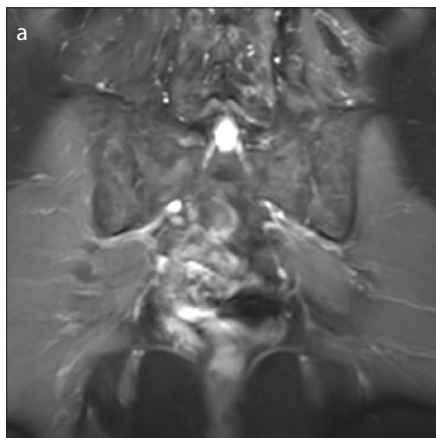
a–e. A 78-year-old female presenting with buttock pain and back pain and diagnosed with left piriformis syndrome. She received an injection without Botox and had a negative response. Coronal 3D IR TSE image (a) shows normal signal of the sciatic nerves. Coronal MIP DTI image ($b=600 \text{ s/mm}^2$) (b) shows no enhancement of the sciatic nerves. Axial T1-weighted image (c) shows left piriformis hypertrophy. CT-guided injection (d) without Botox of the left piriformis muscle. Post-injection image (e) of the sciatic nerve (*black arrow*) and medication mixture (*white arrow*).
